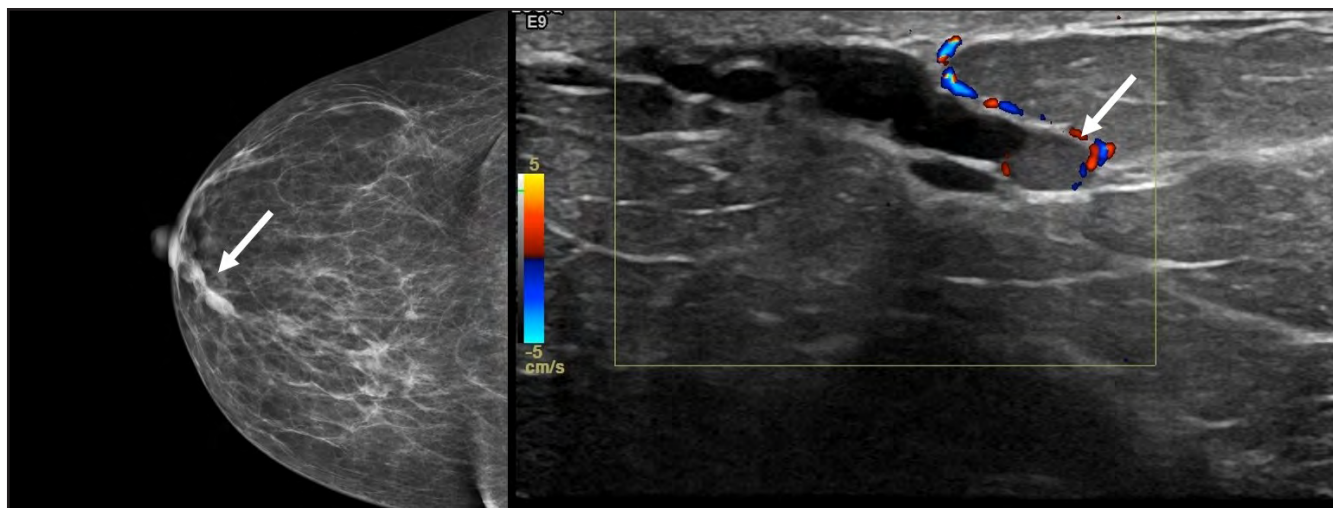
Solitary dilated duct. A 55-year-old woman called back from screening for a solitary dilated duct. CC view from screening demonstrated a solitary dilated duct marked by the white arrow. This persisted on diagnostic mammography and targeted ultrasound was performed. Ultrasound demonstrated a dilated subareolar duct with an intraductal mass demonstrating vascularity at the base. Solitary dilated duct is a special case and should be considered a BI-RADS 4.
